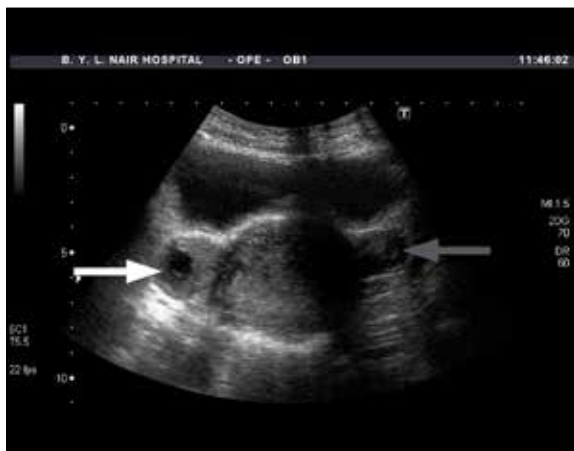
Transabdominal ultrasound depicts upper uterine segment without any gestational sac. Both ovaries appear normal with follicles within them (solid white arrow indicates the right ovary, solid grey arrow indicates the left ovary).
